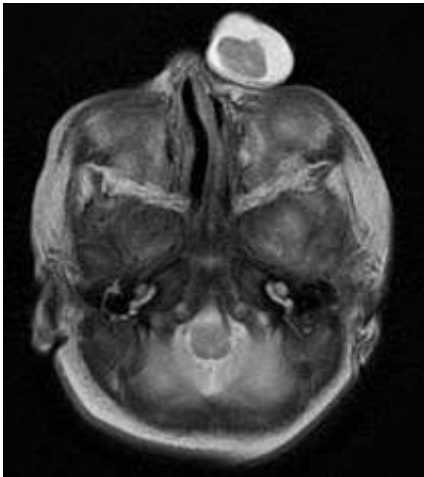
Radiological Assessment on MRI.
